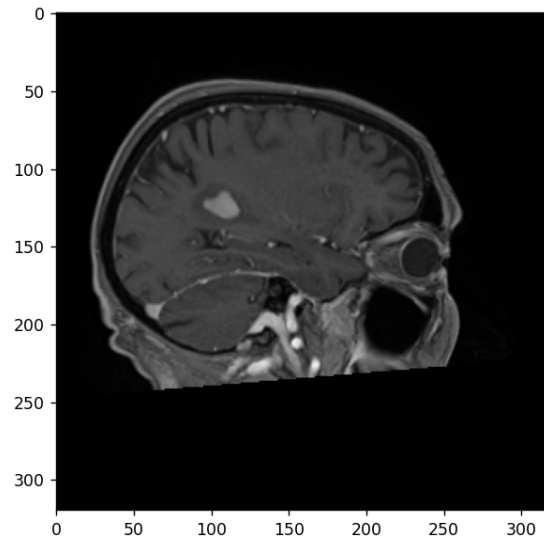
MRI of a patient suffering from a lymphoma
